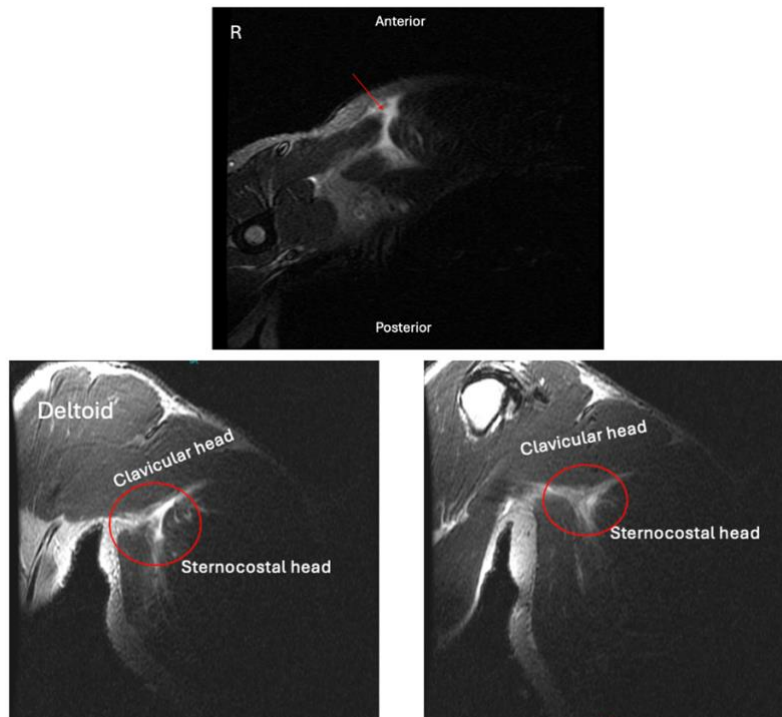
Preoperative axial (top) and coronal (bottom) STIR sequence MRI images demonstrating tear with surrounding edema of the pectoralis major at the myotendinous junction. Tear location was measured at 8.2 cm medial to its insertion on the humerus.
